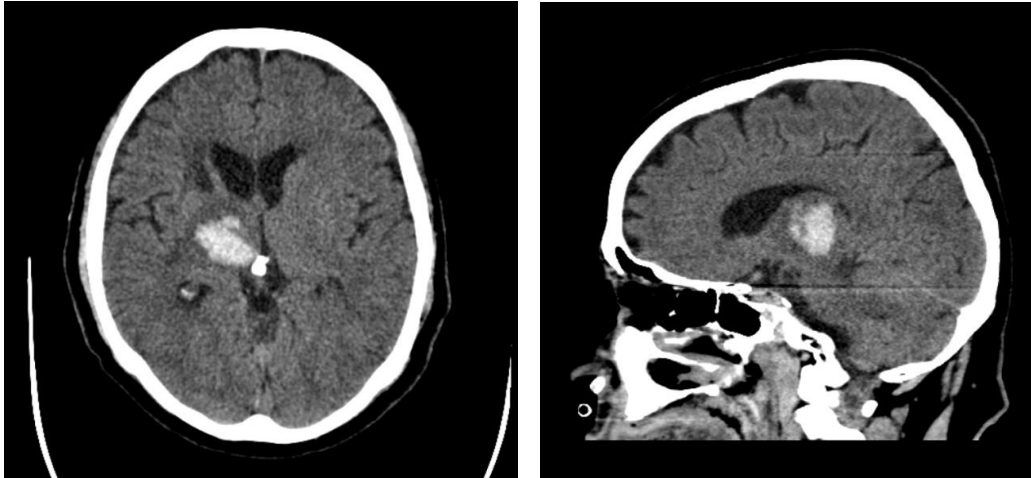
Computed tomography demonstrates a round, hyperdense focus at right thalamic nucleus level, in keeping with a hematoma(Jones et al., 2016).
